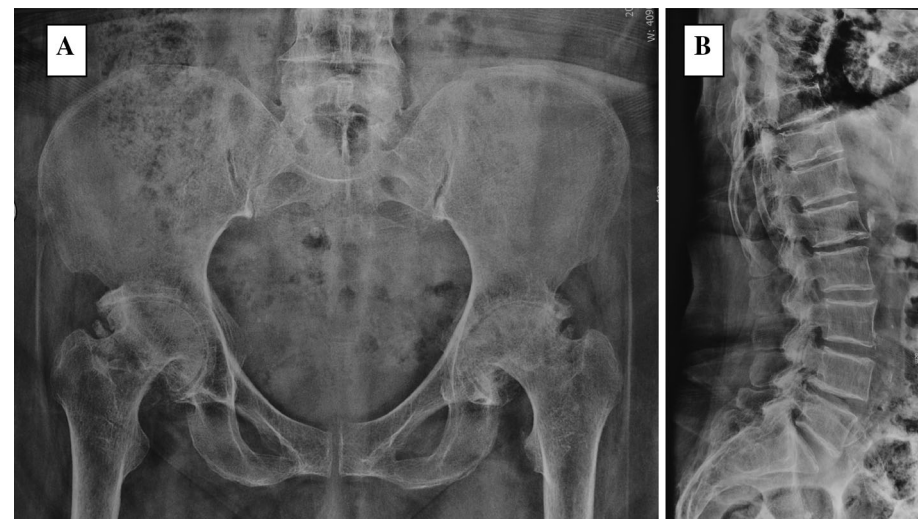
a Radiograph of proband's grandmother's pelvis showing degenerative changes in the hip joints which had flattened acetabular roofs, dysplasia of the femoral heads epiphyses, marginal osteophytes, cystic and joint space narrowed. b The lateral view of the spine shows thoracic hyperkyphosis as well as platyspondyly
